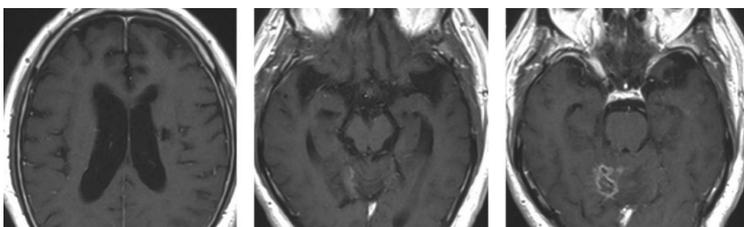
Follow-up of the enhanced-contrast MRI after 3 years of treatment
